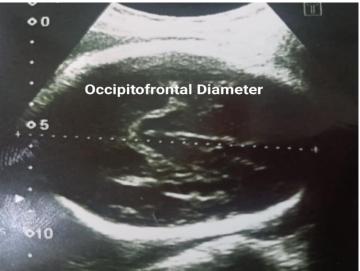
Ultrasonic image showing caliper measuring OFD showing 33W+6d pregnancy.
